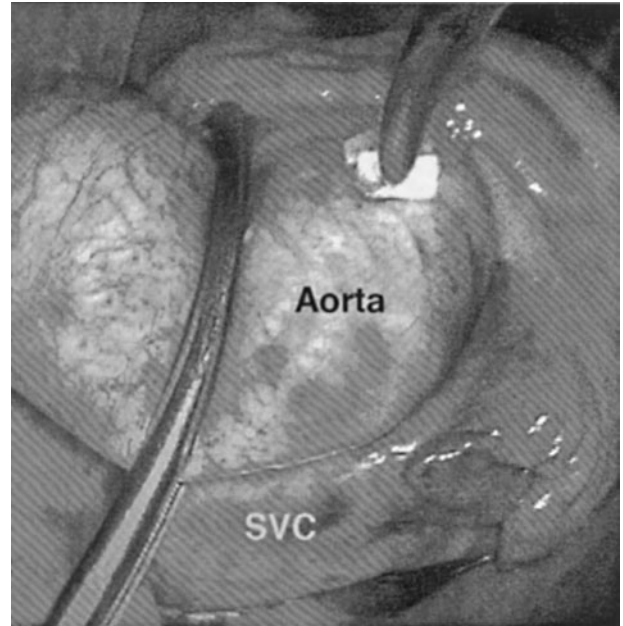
Flexible arm Cosgrove Aortic Clamp (V Muller Inc.). This mobile arm clamp allows complete aortic occlusion through limited access incisions, such as the ministernotomy. We have also used it for transthoracic aortic occlusion in mitral valve surgery.
